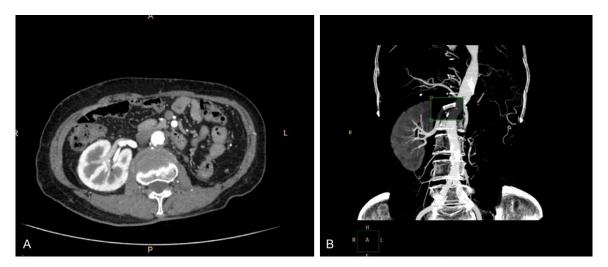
The enhanced CT scan (A) and the three-dimensional visualization CT (B) of abdomen showed no residual renal artery stenosis after PTRAS.
